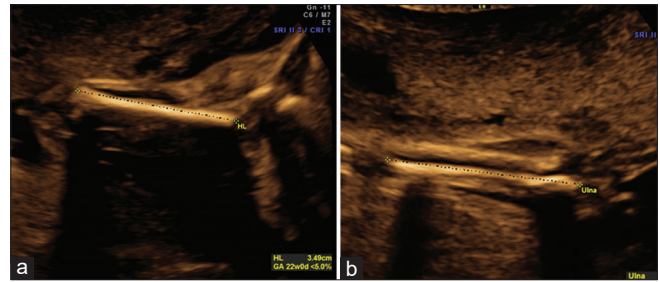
Ultrasound images of the upper limb bones, humerus (a) and ulna, and radius (b) in a fetus with Stuve–Wiedemann syndrome
